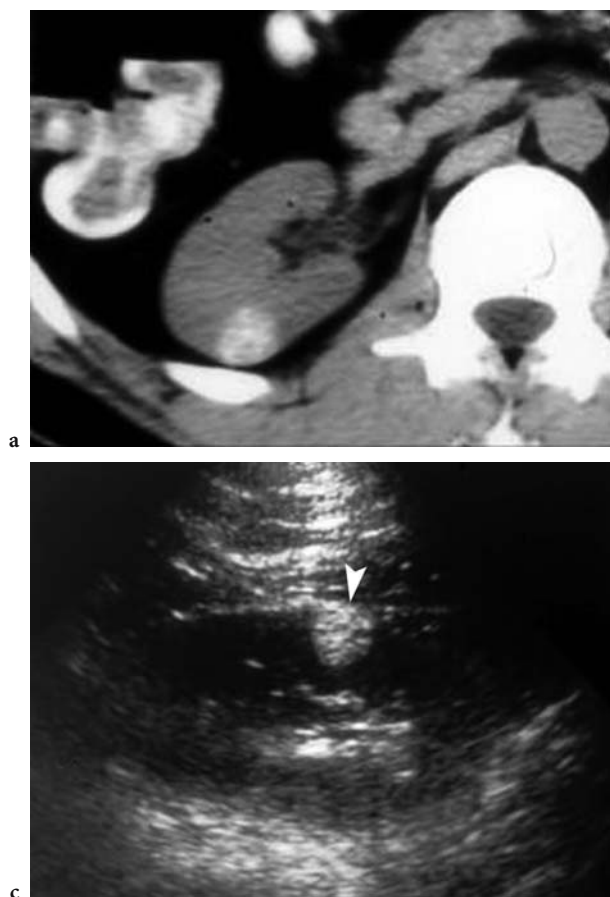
Hyperdense nodule in a 44-year-old man with surgically proven renal papillary adenocarcinoma. a Axial unenhanced CT scan shows incidentally found 1.8 cm hyperdense nodule (79 HU) in the right kidney. b Axial contrast-enhanced CT scan shows near isodensity with the enhancing renal parenchyma on excretory phase image (*arrowhead*). The lesion increased by 20 HU. c Sagittal US of the right kidney shows a highly echogenic lesion (*arrowhead*). (With permission from CURRY 1995; image courtesy of D. Cammoun)
